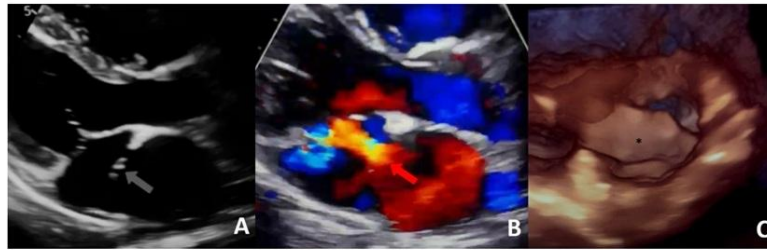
Transthoracic echocardiogram showing cor triatriatum sinister (arrow) in two-dimensional (A) and color Doppler mode (B). Three-dimensional reconstruction (C) demonstrated that the cor triatriatum membrane (asterisk) occupied 74% of the transverse area of the left atrium.
